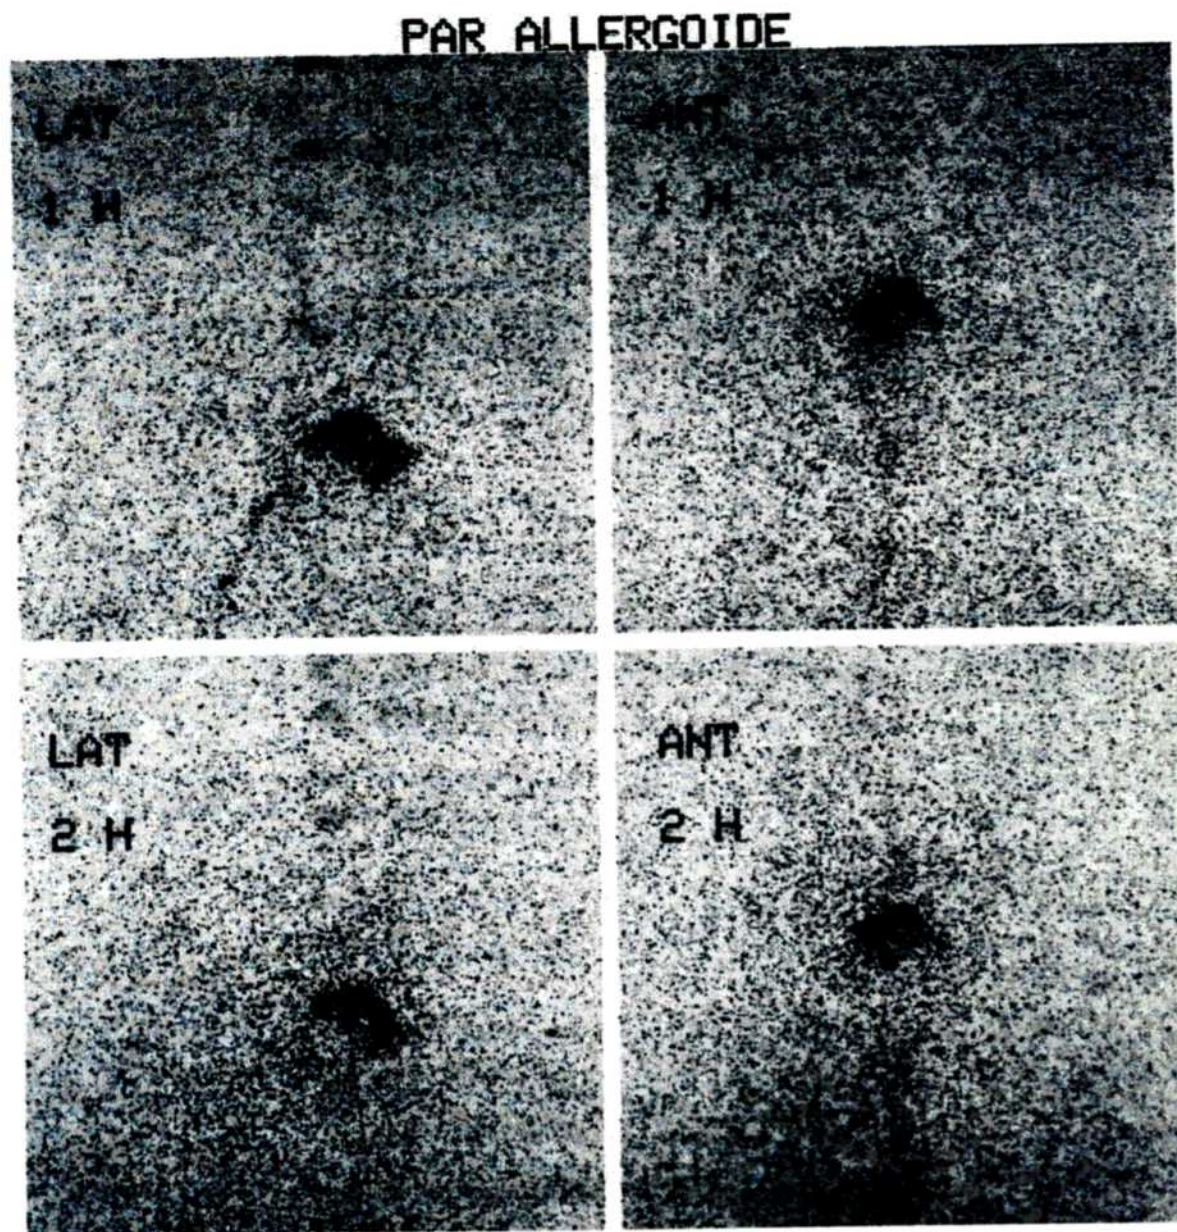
Static scintigraphic imaging of the head, acquired 1 hour (upper images) and 2 hours (lower images) after the administration of the tablet containing the radiolabelled allergoid. The lateral view (on the left) and the anterior view (on the right) show the persistence of radioactivity in the mouth even after rinsing.
